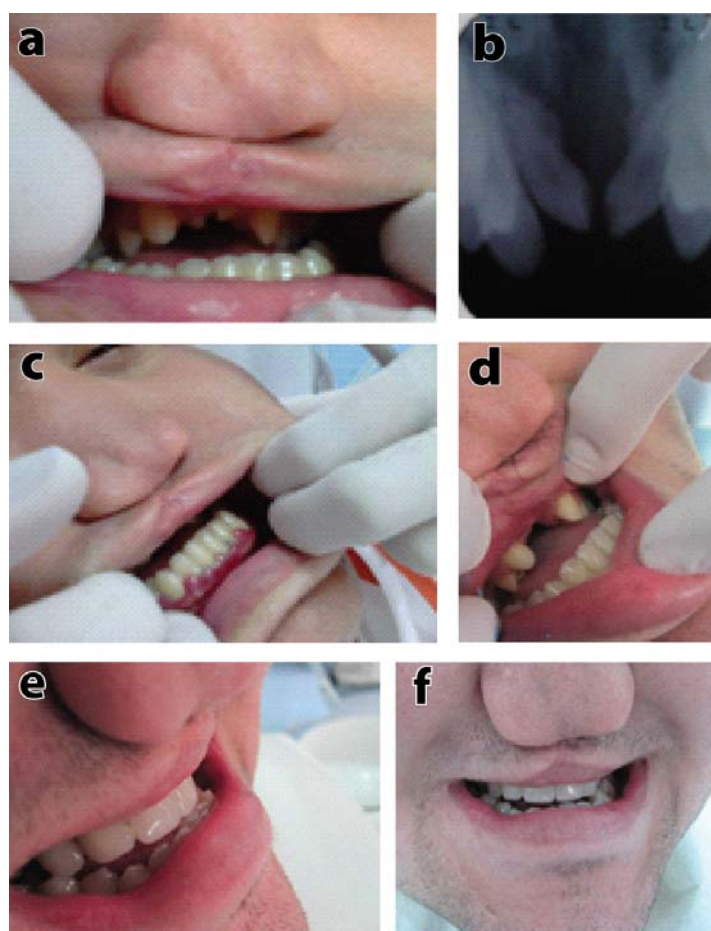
a) Micromaxilla; b) X-ray showing the malpositioned teeth; c) Gingival inflammation; d) Abutment teeth after preparation; e) Metal-ceramic fixed partial denture seated in the patient mouth; f) Appearance after prosthodontic rehabilitation.
